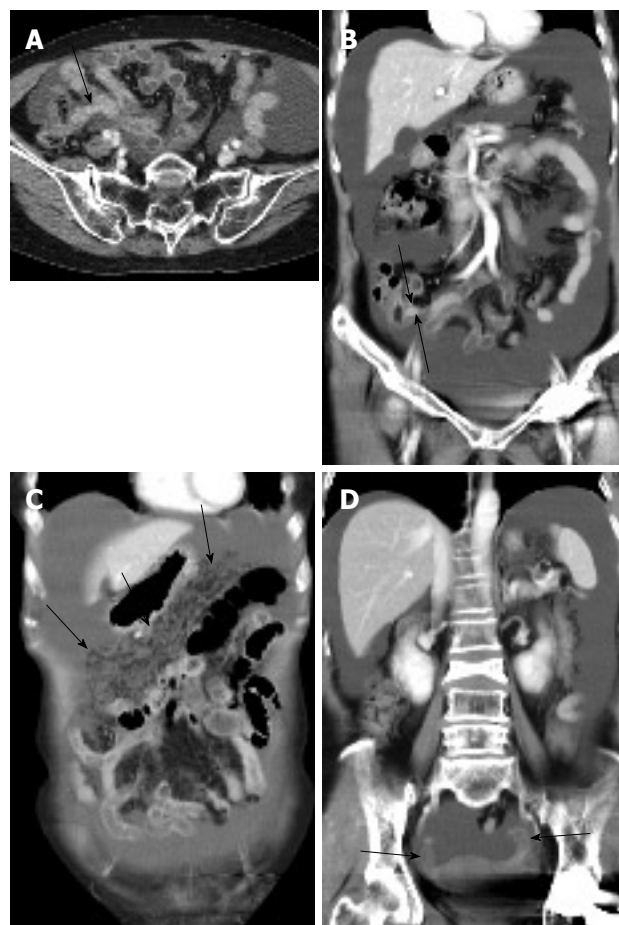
Contrast enhanced CT axial scan (A) and coronal reformatted image (B) showing massive ascites in abdominal cavity. Appendix is prominently seen with mild thickening (arrowed). Coronal reformatted images (C and D) showing increased reticulonodular densities (arrows in C) along the omentum representing carcinomatosis peritonei with no definite evidence of mass like lesion in adnexa (arrows in D).
